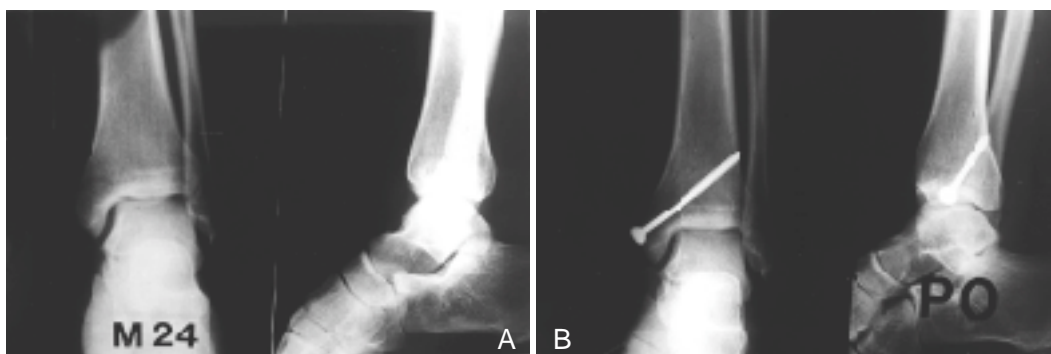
24-year-old man. Initial radiograph showed transverse fracture of medial malleolus with displacement of 2mm.
